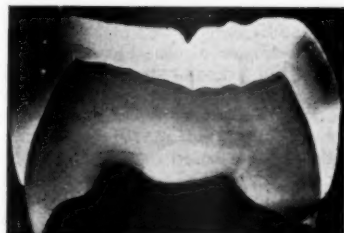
Radiograph ( $\times 5$ ) of an unerupted molar from the same case, showing localized zones of hypocalcification in both buccal and lingual enamel.
